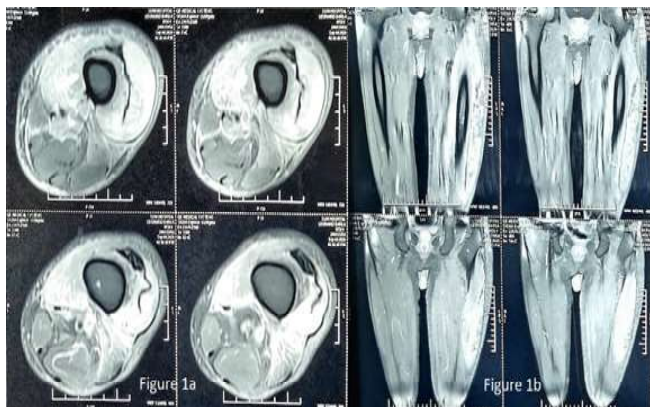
Magnetic resonance imaging (MRI) showing thickened vastus lateralis, intermedius, medialis, adductor longus and brevis muscle of left thigh (Figure 1a) with altered signal intensity and heterogenous post-contrast enhancement without any collection or bone involvement (Figure 1b).
